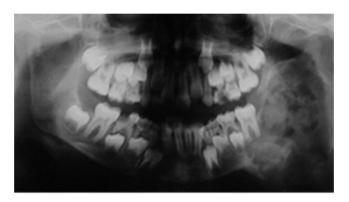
Initial panoramic radiograph showing patient in mixed dentition and presence of destructive lesion with poorly defined margins and a predominantly mixed radiographic pattern in the left mandibular body, angle and ramus.
